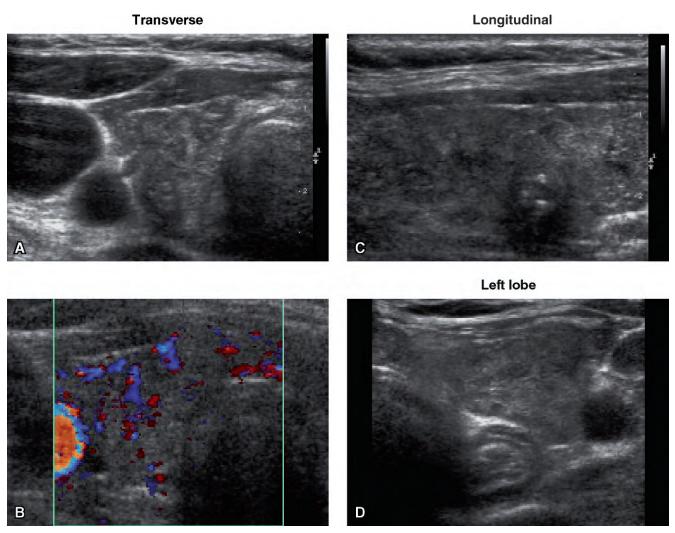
Ultrasound of thyroiditis in both lobes. A, Transverse. B, Color Doppler, transverse. C, Longitudinal. D, Left lobe longitudinal.
